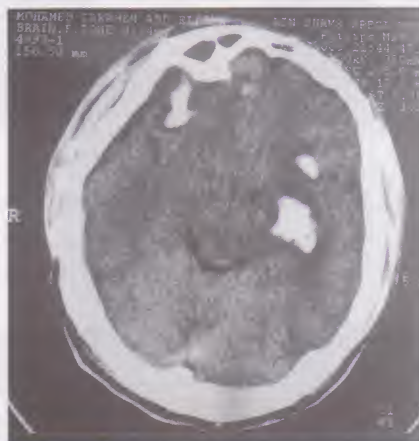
Axial CT brain showing multiple hyperdense areas of fresh blood density in the right frontal and left temporal lobes denoting bilateral hemorrhagic contusions
